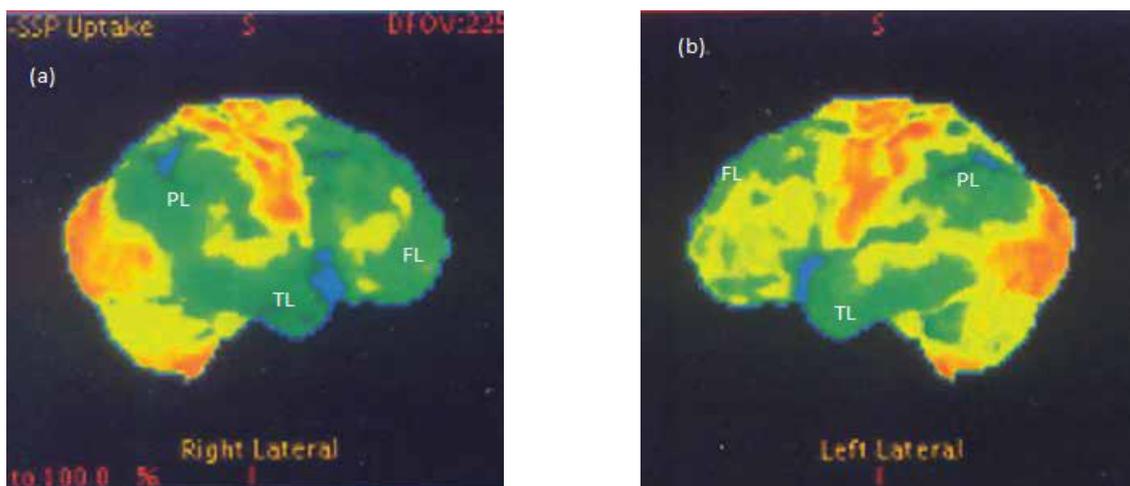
Fluorodeoxyglucose positron emission tomography (FDG PET) brain scan in Alzheimer's disease (AD) Brain FDG PET scan in moderately severe AD: right lateral (a) and left lateral (b) symmetrical hypometabolism affecting temporal (TL), parietal (PL), and frontal (FL) lobes
